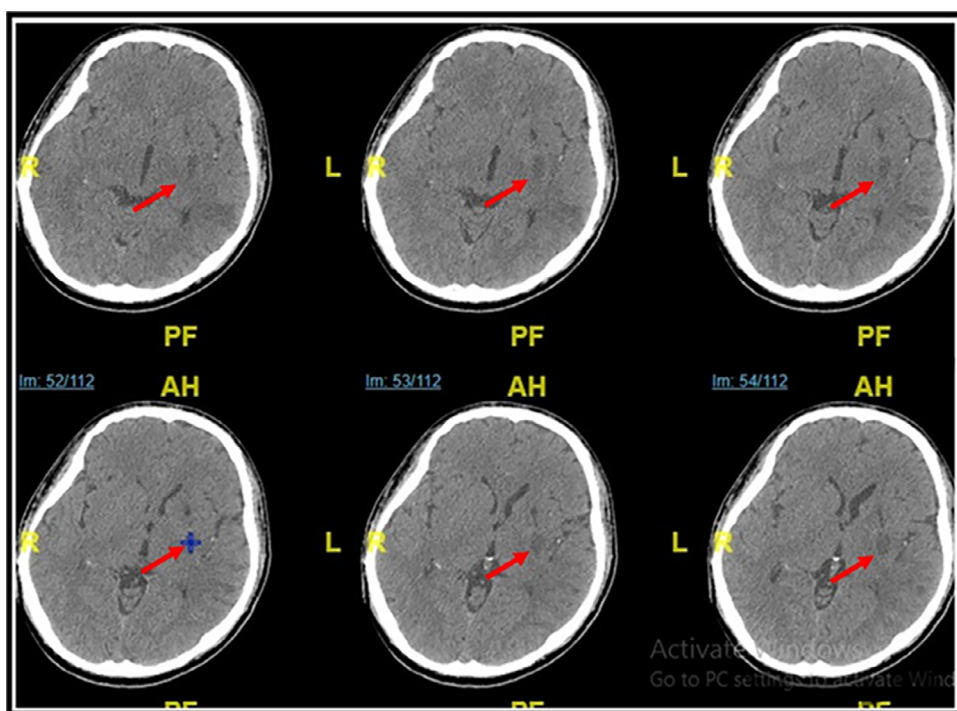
Head CT-Scan examination without contrast. Onset 14 hours before admission to the hospital. There was an infarction in the external capsule and left corona radiata (showed by red arrow).
